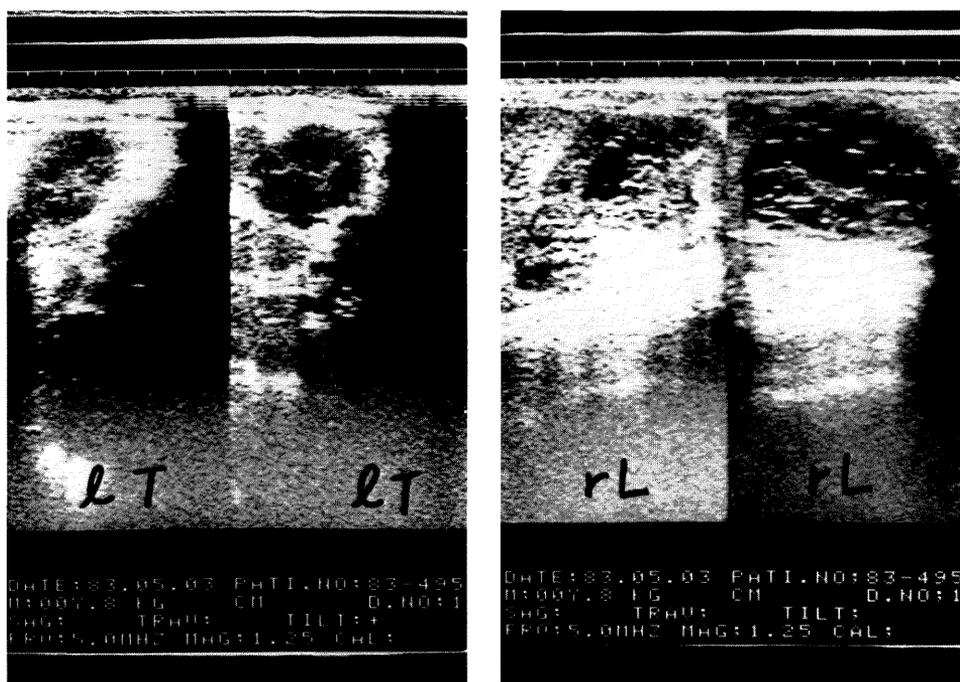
Ultrasound scanning (USG). Ultrasound scanning showed a right sonar lucent mass with numerous curvilinear internal echoes.
